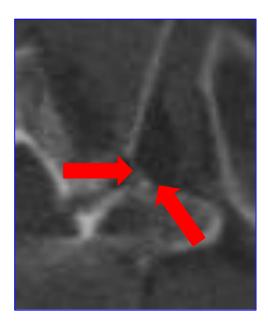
CT scan with bone algorithms: verification of the correct positioning of the needle at the lysis point (arrows).
